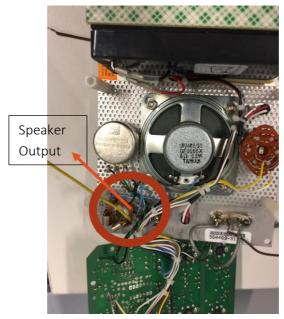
OUTPUT FROM ULTRASOUND BLOOD FLOW MONITOR
